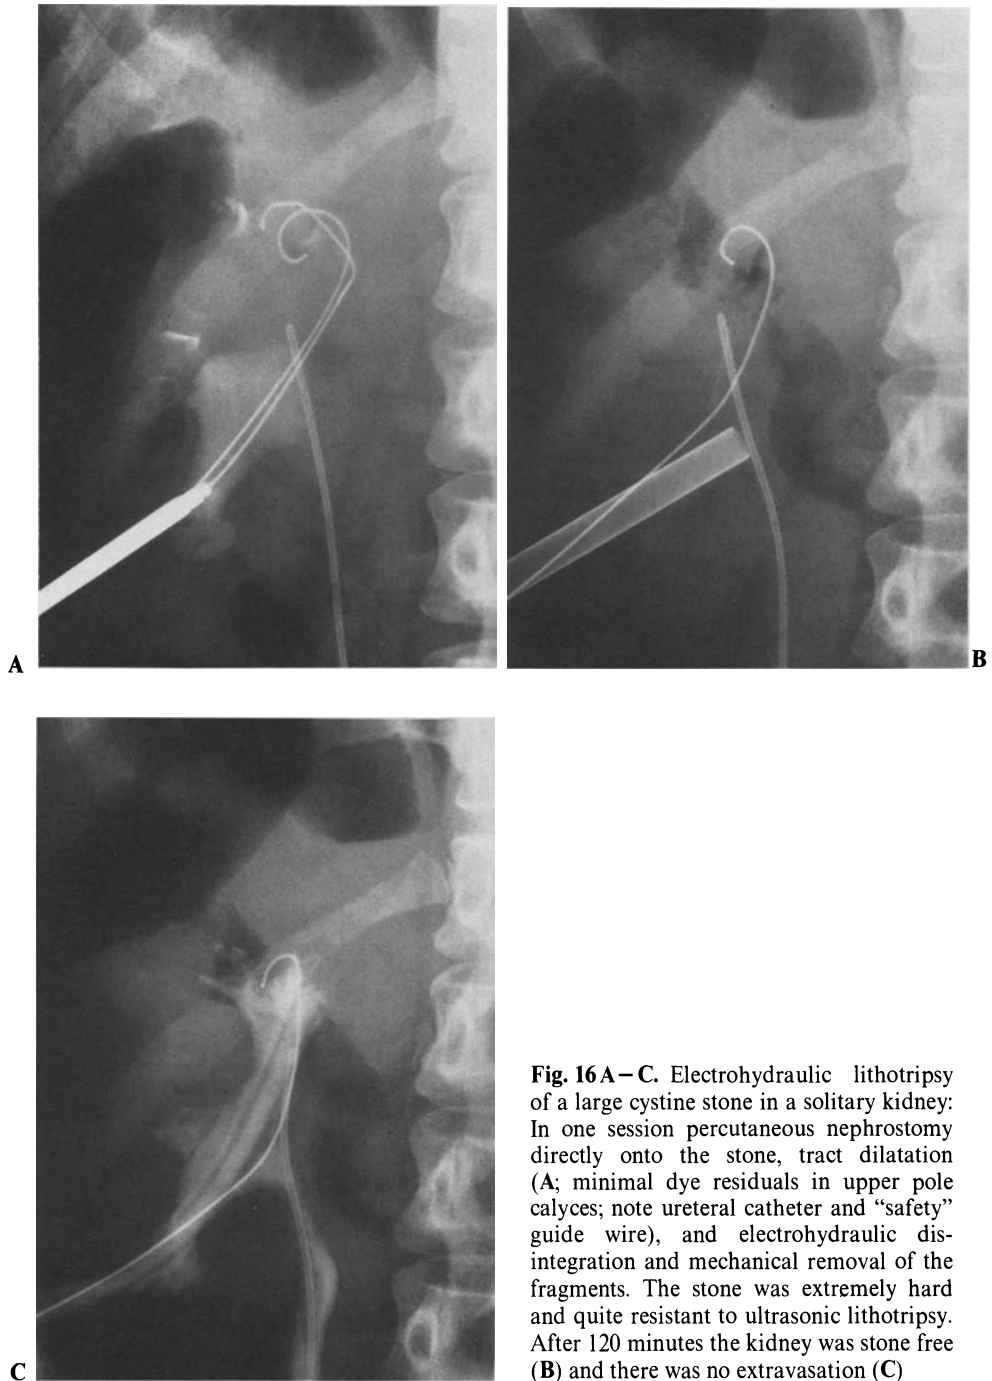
A–C. Electrohydraulic lithotripsy of a large cystine stone in a solitary kidney: In one session percutaneous nephrostomy directly onto the stone, tract dilatation (A; minimal dye residuals in upper pole calyces; note ureteral catheter and “safety” guide wire), and electrohydraulic disintegration and mechanical removal of the fragments. The stone was extremely hard and quite resistant to ultrasonic lithotripsy. After 120 minutes the kidney was stone free (B) and there was no extravasation (C)
